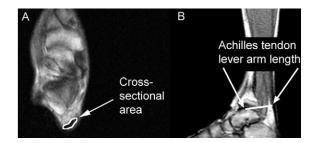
(A) Achilles tendon cross-sectional area and (B) lever arm length were calculated from magnetic resonance images. The lever arm length was defined as the perpendicular distance from the midpoint of the superior surface of the trochlea of the talus to the line of action of Achilles tendon. Ankle angle was 90 deg. (sole of the foot perpendicular to shank).
